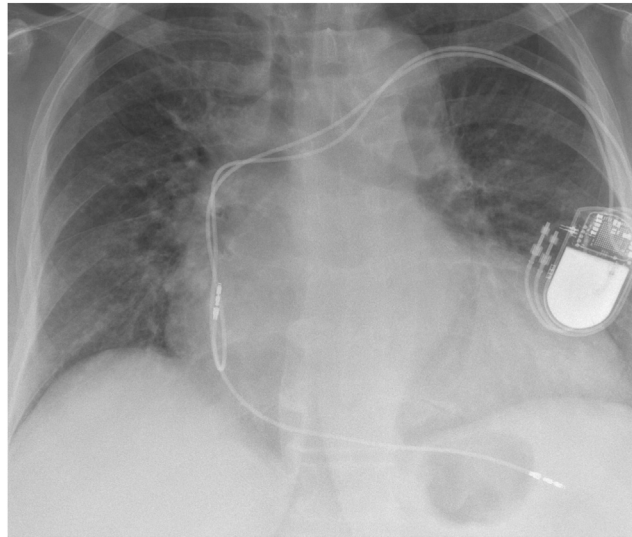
Preoperative chest radiograph with implanted dual-chamber pacemaker.
